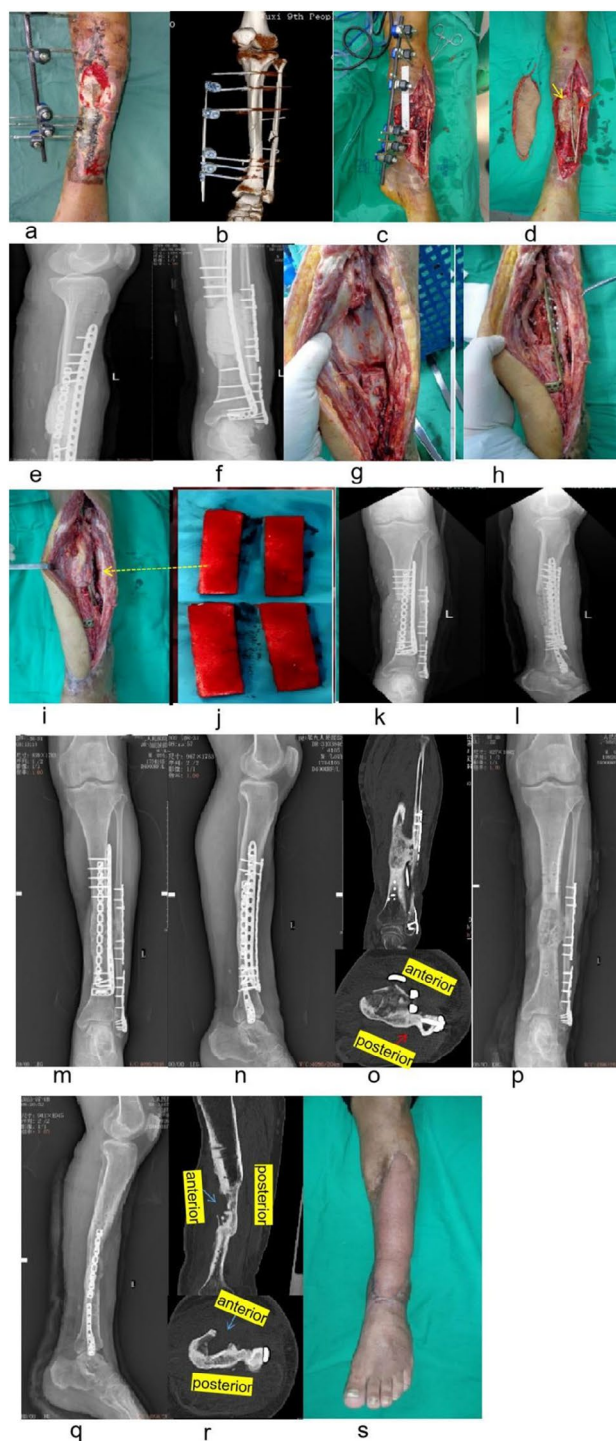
A 54-year-old male patient with tibial defects treated using IMT and IMBMLITFF. (A) The appearance and (B) CT reconstruction revealed fractures of the tibia and fibula, along with soft tissue necrosis and defects. (C) After debridement, there were large segmental tibial and soft tissue defects. (D) PMMA spacers were independently inserted into the tibial defect (yellow arrow) and between the tibia and fibula (red arrow), and a free anterolateral femoral skin flap was used to repair the wound. (E, F) X-rays showed the cement spacers placed in the tibial defect and between the tibia and fibula. (G) During the second stage of the IMT, the spacer was removed. (H) Autologous bone was grafted at the tibial defect. (I, J) Several hemostatic sponge pieces, soaked in bone marrow fluid from the iliac bone graft harvesting site, were inserted into the IM space between the tibia and fibula. (K, L) Instant X-rays, after the second stage IMT procedure showed uniform bone grafting. (M, N) X-rays and (O) CT scans at 8 months postoperatively showed callus bridging the posterior tibial side and the TFF site, but not the anterior tibial and medial sides. (P, Q) X-rays and (R) CT scans at 12 months postoperatively showed clinical healing of the tibial defects, with a loss of the anterior tibial cortex. (S) The appearance at 12 months postoperatively shows good function
